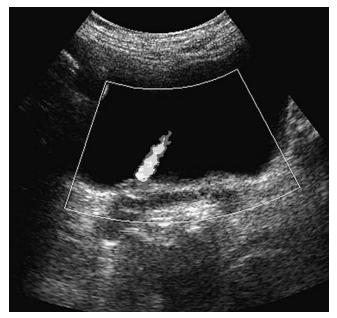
Transverse Doppler sonogram (see color plate 5).
